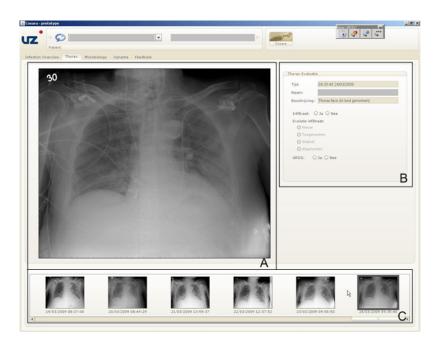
Screenshot of the chest X-rays (A,C) with feedback form (B), retrieved from the PACS system, in the COSARA client.
